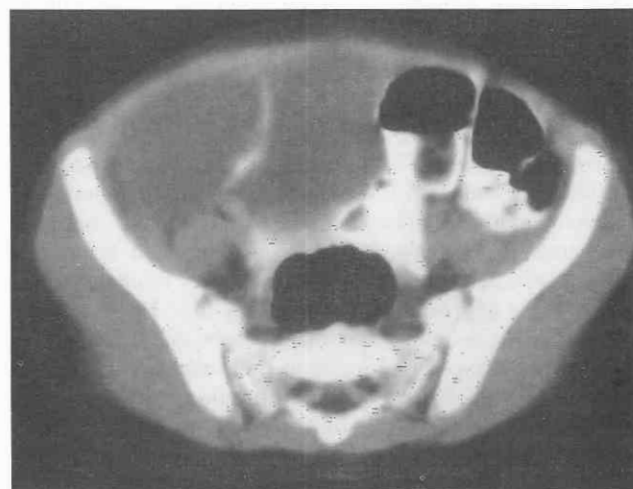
Mesenteric lymphangioma. CT scan through the pelvis shows a thin-walled, septate cystic mass.
